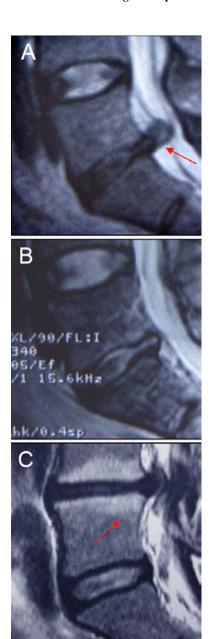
A case example for autologous disc cell transplantation, reproduced with permission from © Springer-Verlag Berlin Heidelberg 2006 (209): (A) 34-year-old man with lumbar disc herniation at L5/S1 (red arrow); (B) MRI one year post-transplantation with increased hyperintensity of the IVD in T2-weighted imaging, indicating good recovery of the disc. (C) 41-year old woman suffering from degenerated disc disease L4/5 (red arrow). Note reduced disc height, hypointensity in the IVD and inflammatory processes in the adjacent vertebral bodies
